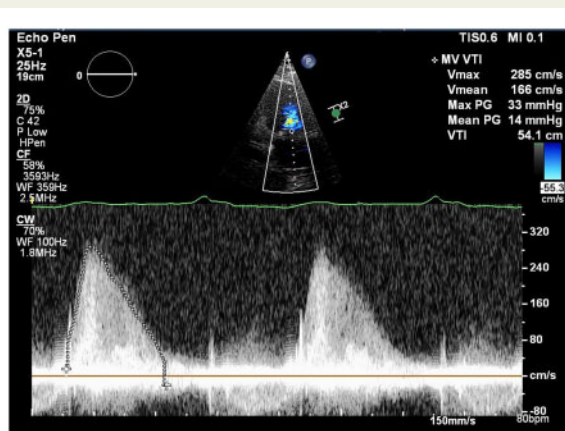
Transthoracic echocardiogram with continuous wave Doppler demonstrating increased transmitral gradient and normal pressure half-time suggestive of occult mitral paravalvular leak with acoustic shadowing by prosthesis.
